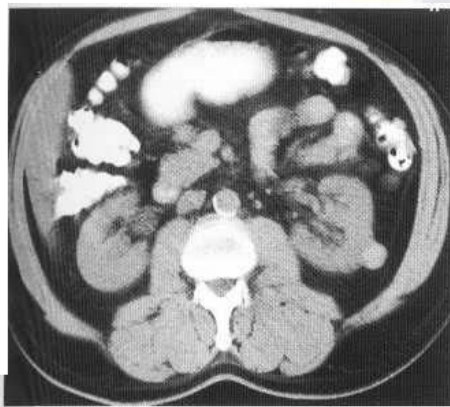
Renal cyst on ultrasound (A) appearing as a well-defined echo-free mass without significant wall thickness and distal acoustic enhancement. On CT the cyst is of water density (B) and shows no enhancement with intravenous contrast (C). On MRI the cyst has the same signal intensity as water, being low signal on the T₁-weighted sequence (D) and high signal on the T₂-weighted sequence (E).
